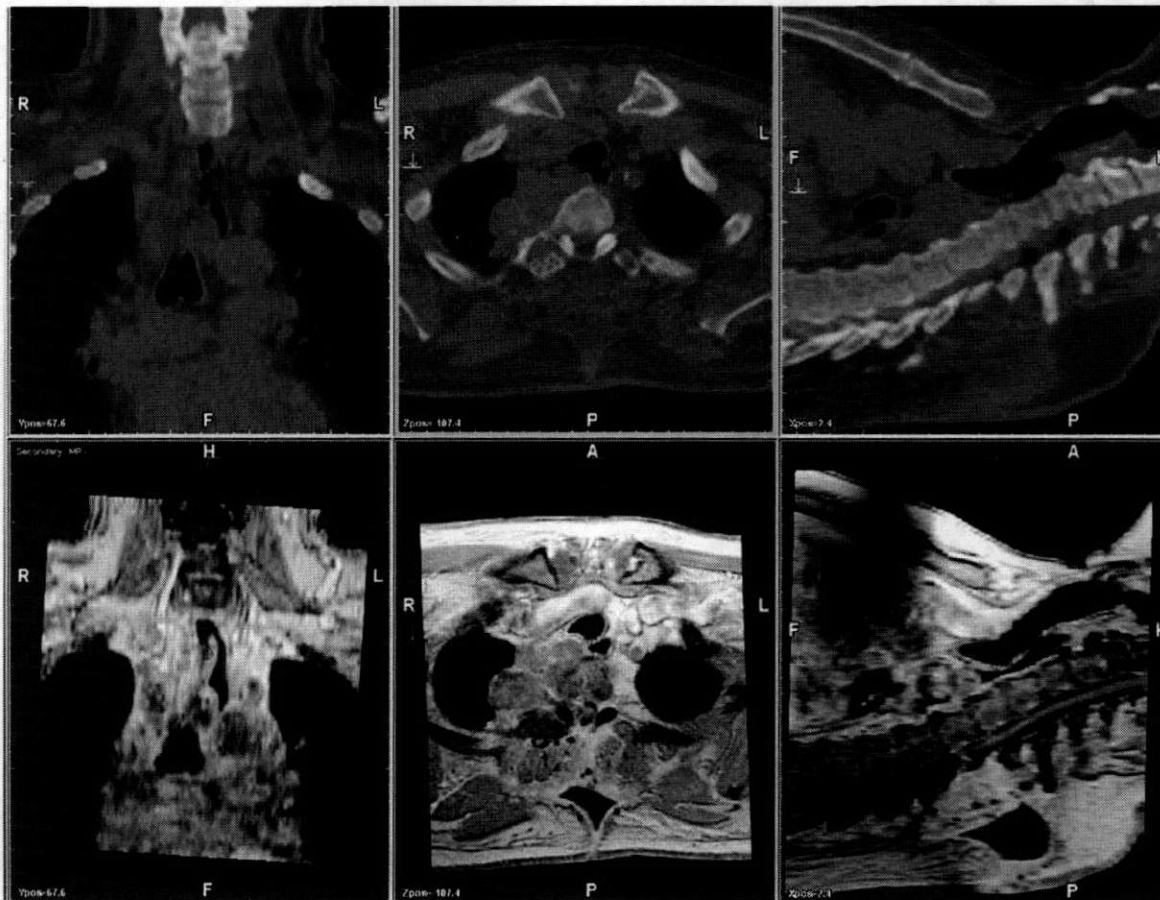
Registered computed tomography (top row) and magnetic resonance (bottom row) scans. Coronal and sagittal reformats are left and right of the original transaxial scans. In magnetic resonance, a flat table top, a plastic head rest and a 'vac bag' shoulder/neck rest were used.
